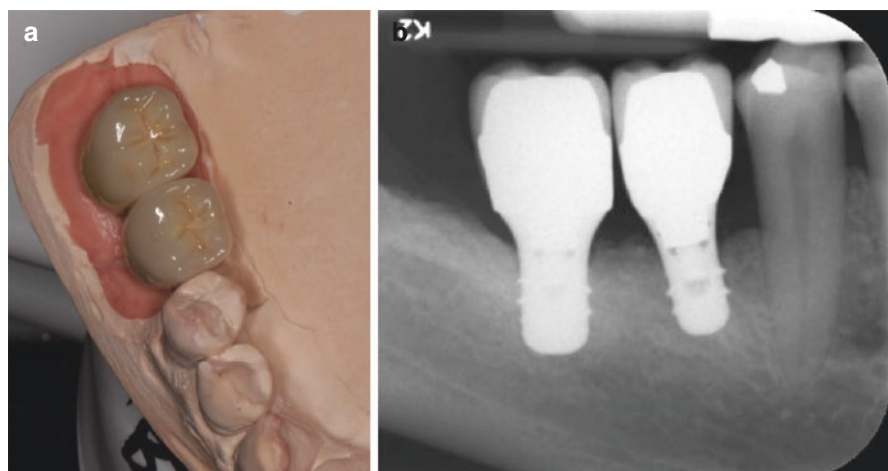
Cement-retained implant crowns have potential for optimal esthetics. Given no screw access hole also exhibits excellent durability and good control over the occlusal surface. (a) Cement-retained metal ceramic implant crowns on final cast made to restore tissue level implants at sites #30 and #31. (b) Follow-up periapical radiographs (Photos courtesy of Dr. Konstantinos Vazouras)
